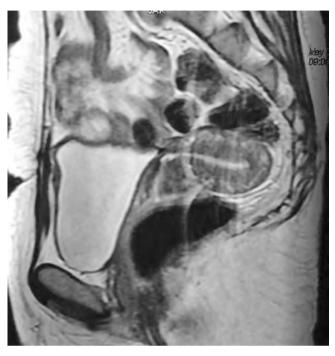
MRI showing fistulous connection between posterior wall of bladder and uterus
